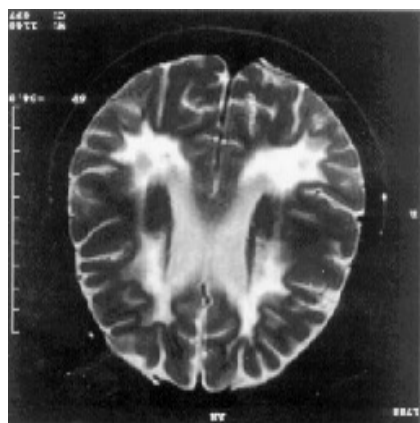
Case No 1. A T2-dependent MRI-CT image of the axial brain section. Extensive demyelination areas in the form of irregular hyperdense foci around the cornua of the lateral brain ventricle.
